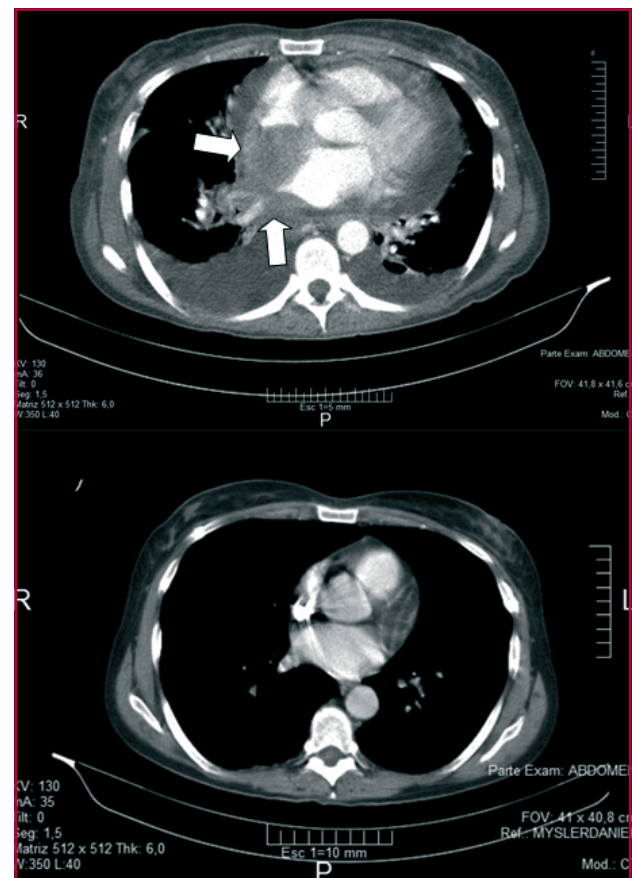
Pretreatment chest computed tomography (CT) scan (1A top): mediastinal mass in close contact with right to left atria (arrows), bilateral pericardial and pleural effusion. Post-treatment chest CT scan (1B bottom): absence of enlarged lymph nodes, pleural or pericardial effusion.
